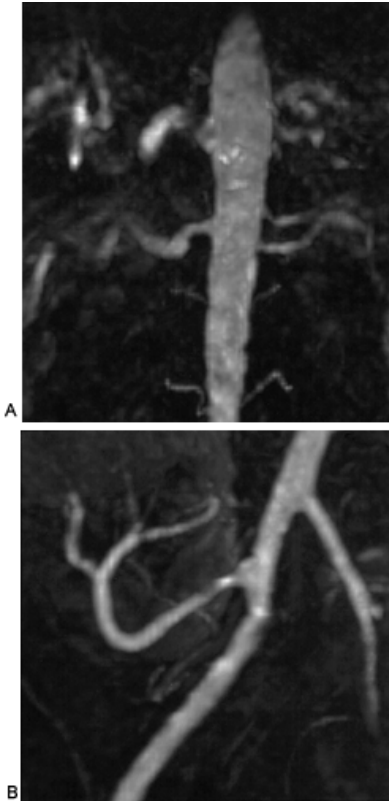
Spiral computed tomography scans showing bilateral renal artery stenosis (A) and stenosis of a transplant renal artery (B).
